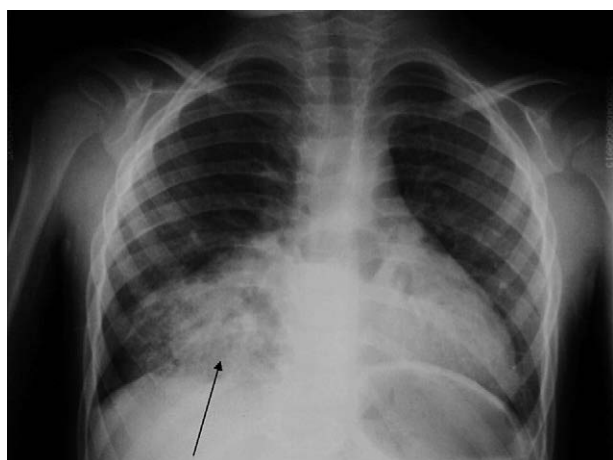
Posterior-anterior chest radiograph shows a massive right lower lobe infiltrate.
